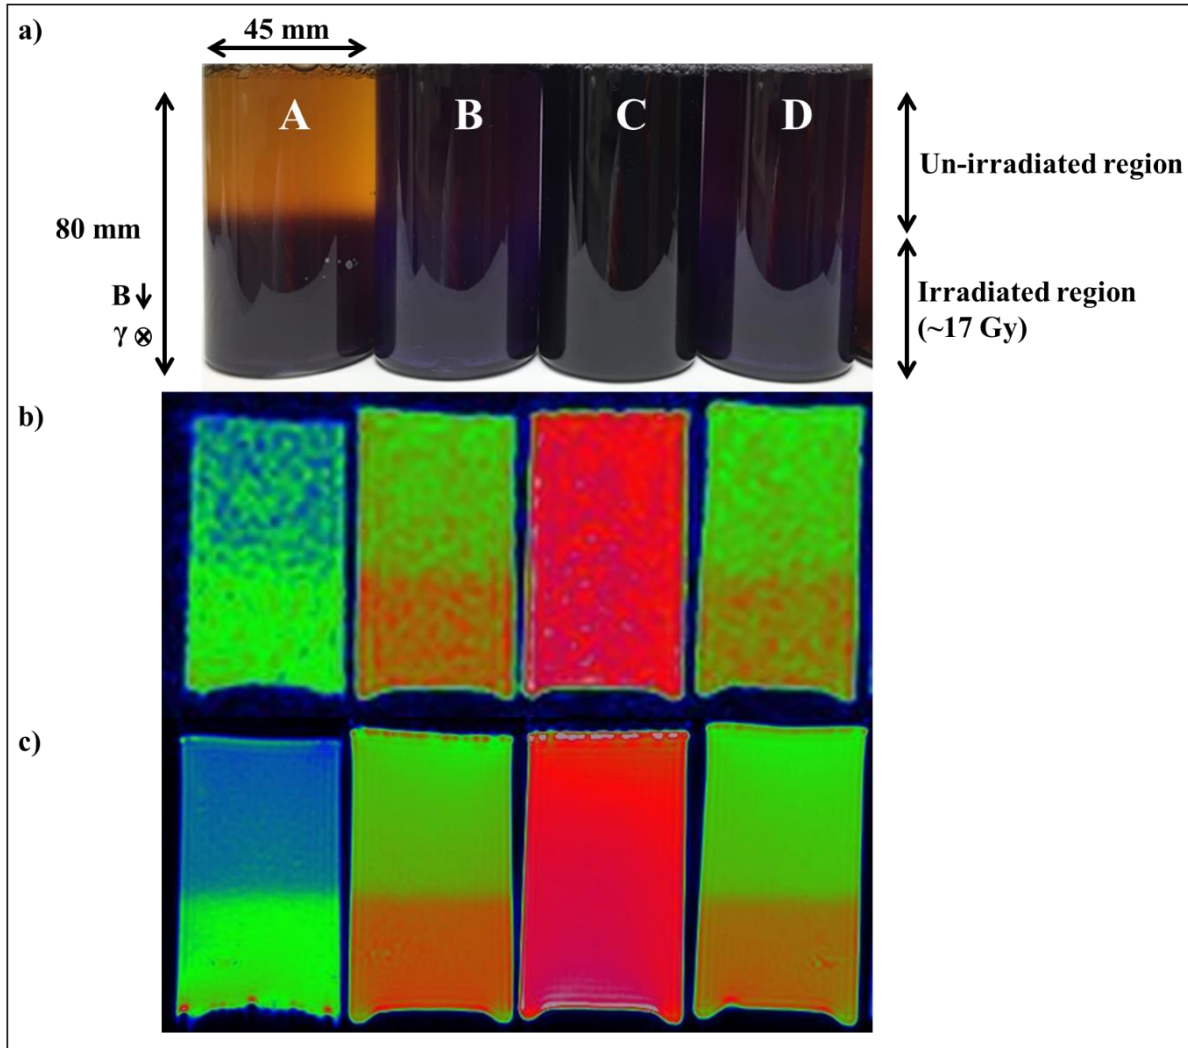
a) Pictures of physical dosimeters where A – FOX, B – FCX, C – FPX, and D – FXG. The top half of each gel was not irradiated, and the bottom half was irradiated to approximately 17 Gy. b) Snapshots of bFFE acquisitions with $TR/TE = 5/2.4$ ms. c) Post-irradiation acquisitions with TSE $TR/TE = 500/20$ ms. MR images shown with color instead of grayscale to emphasize contrast.
